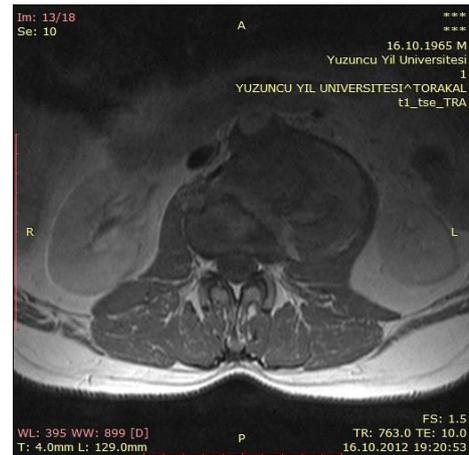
A contrast-enhanced T1-weighted MRI image showing a partial thrombosed lumen of the abdominal aorta and heterogeneous hematoma.
